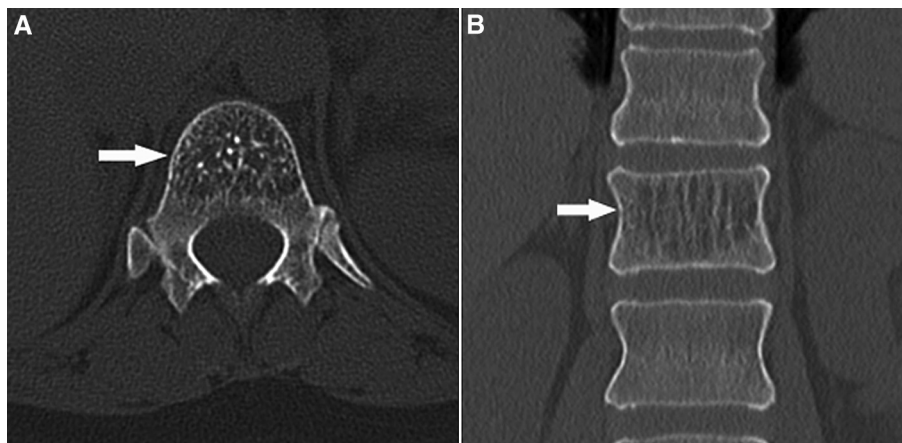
(A, B) A 45-year-old man presented with renal colic underwent a non contrast computed tomography of the abdomen, showing an incidental hemangioma at the L1 vertebral body, with characteristic polka dot (arrow in A) and corduroy and/or honeycomb appearance (arrow in B).
